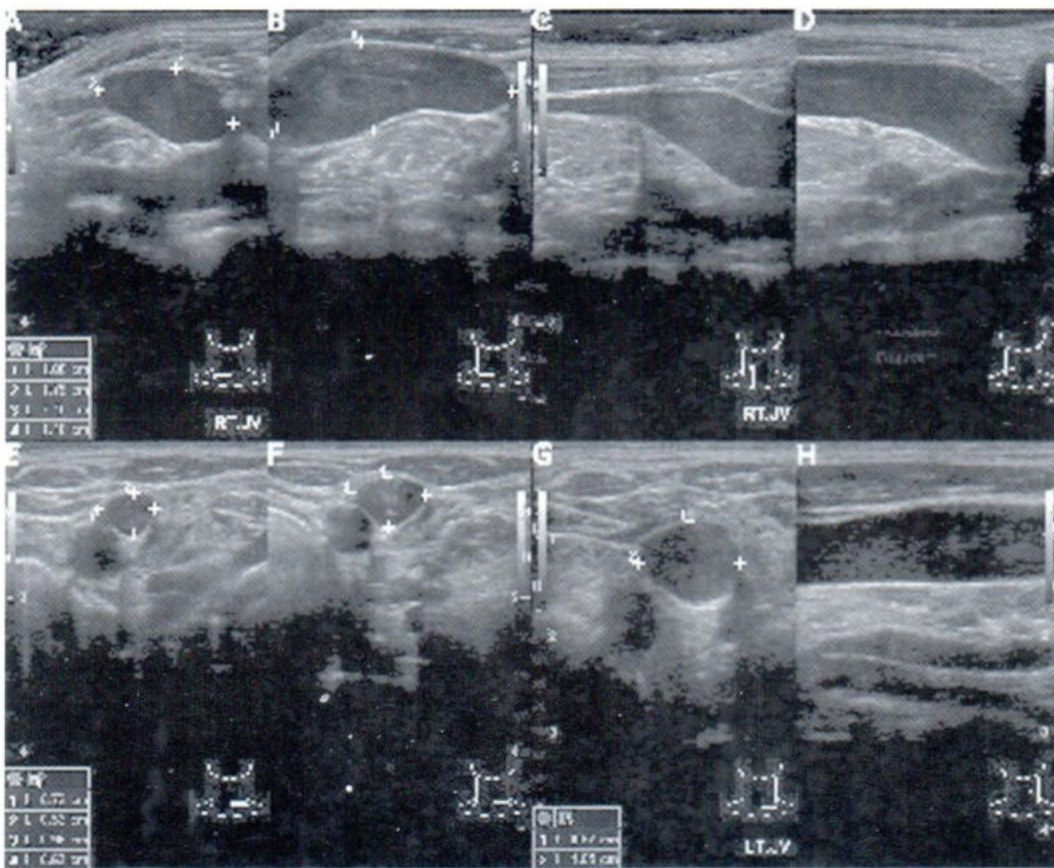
Ultrasonography of right (A-D) and left (E-H) internal jugular veins (caliper). Size of right IJV at rest (A-transverse, and C-longitudinal plane). It is more dilated during Valsalva maneuver (B and D), with the left IJV comparison (E-H).
